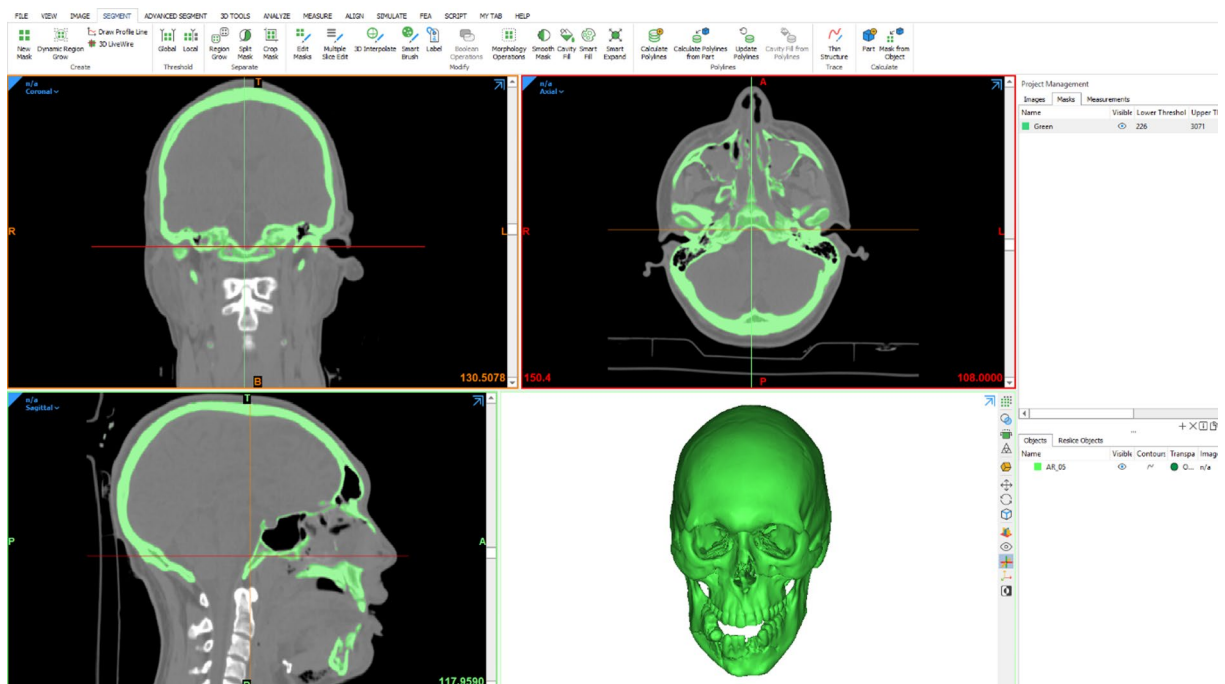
Workstation-based software with simultaneous view of the sagittal, coronal and axial planes of the CT scan and additionally the reconstructed 3D model in editing window.
